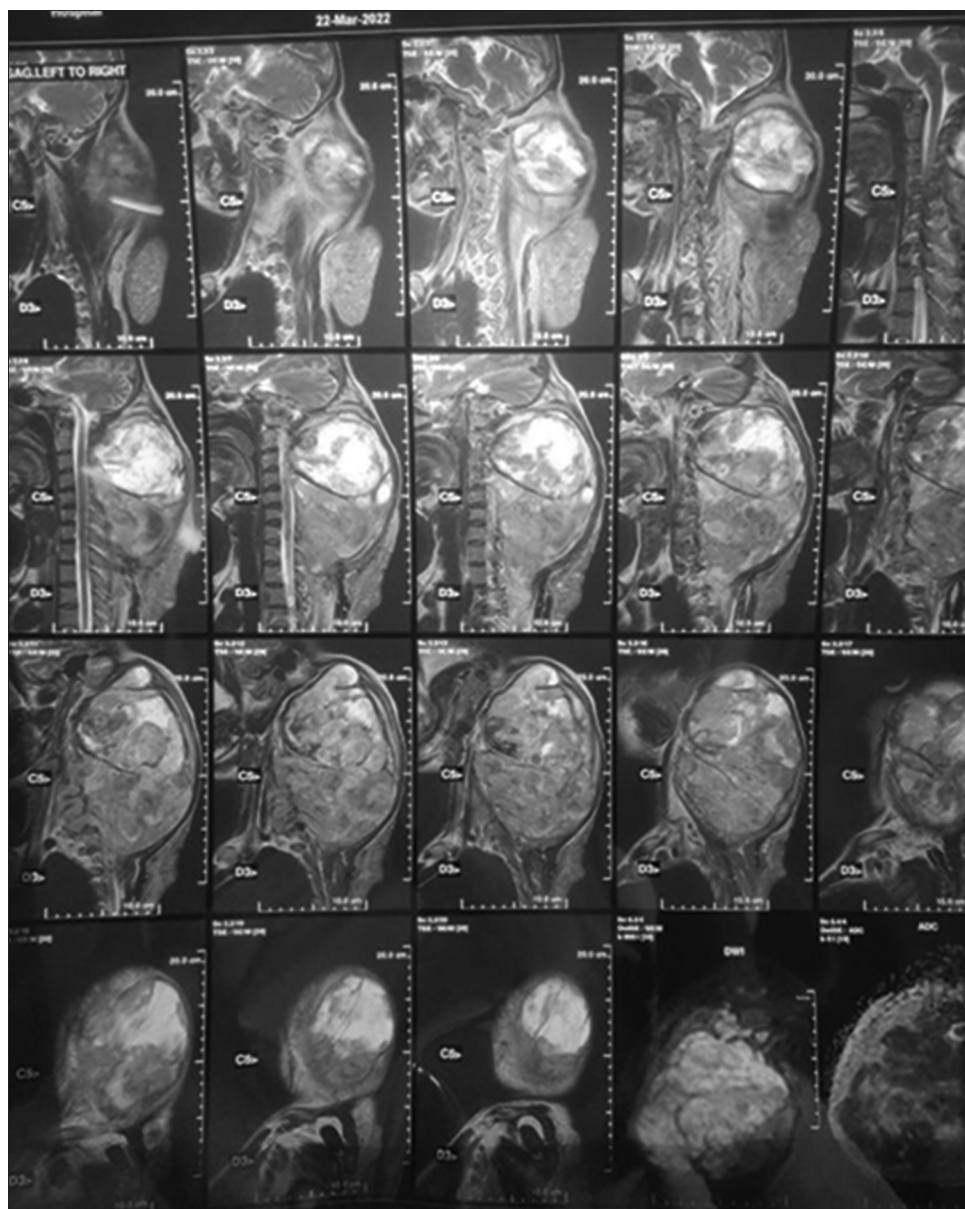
MRI- Showing extent of tumor
